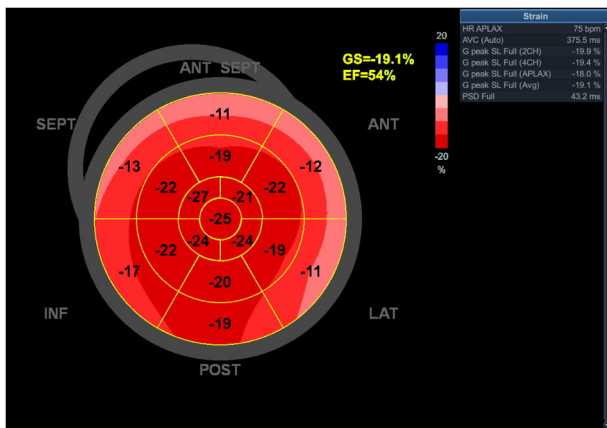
Echocardiography bull's-eye plot recorded after 3 cycles of chemotherapy showing slightly reduced GS, with minimal dyskinesia localized at the level of the basal segments of the antero-lateral, antero-septal, septal and lateral walls and preserved ejection fraction. SEPT, septal wall; ANT, anterior; LAT, lateral wall; POST, posterior; INF, inferior; GS, global longitudinal strain; EF, ejection fraction; AVC, aortic valve closure; HR, heart rate; APLAX, apical long-axis; PSD, peak strain dispersion; G peak SL, global peak longitudinal strain.
